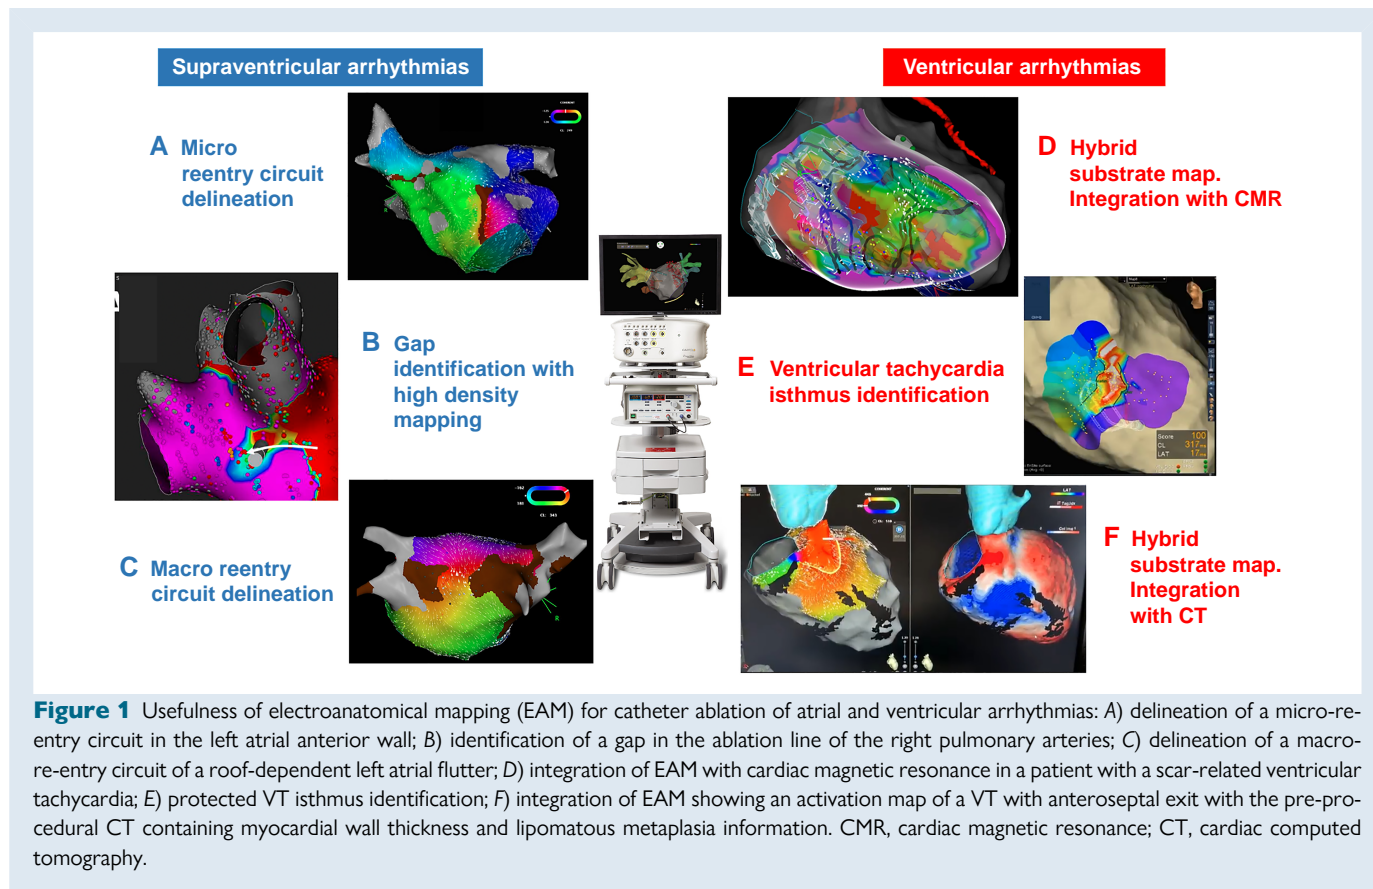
Usefulness of electroanatomical mapping (EAM) for catheter ablation of atrial and ventricular arrhythmias: A) delineation of a micro-re-entrant circuit in the left atrial anterior wall; B) identification of a gap in the ablation line of the right pulmonary arteries; C) delineation of a macro-re-entrant circuit of a roof-dependent left atrial flutter; D) integration of EAM with cardiac magnetic resonance in a patient with a scar-related ventricular tachycardia; E) protected VT isthmus identification; F) integration of EAM showing an activation map of a VT with anteroseptal exit with the pre-procedural CT containing myocardial wall thickness and lipomatous metaplasia information. CMR, cardiac magnetic resonance; CT, cardiac computed tomography.
